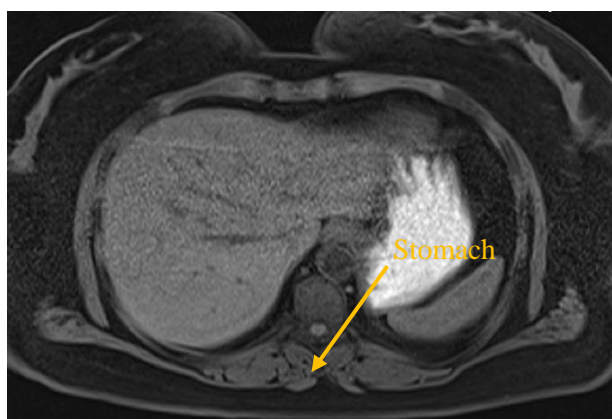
MRI transverse section of abdomen (T1-weighted) under imaging conditions 2-dimensions, Gradient echo sequences.
